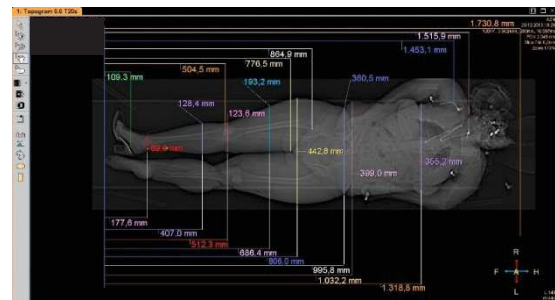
CT scan with measurements [15]
